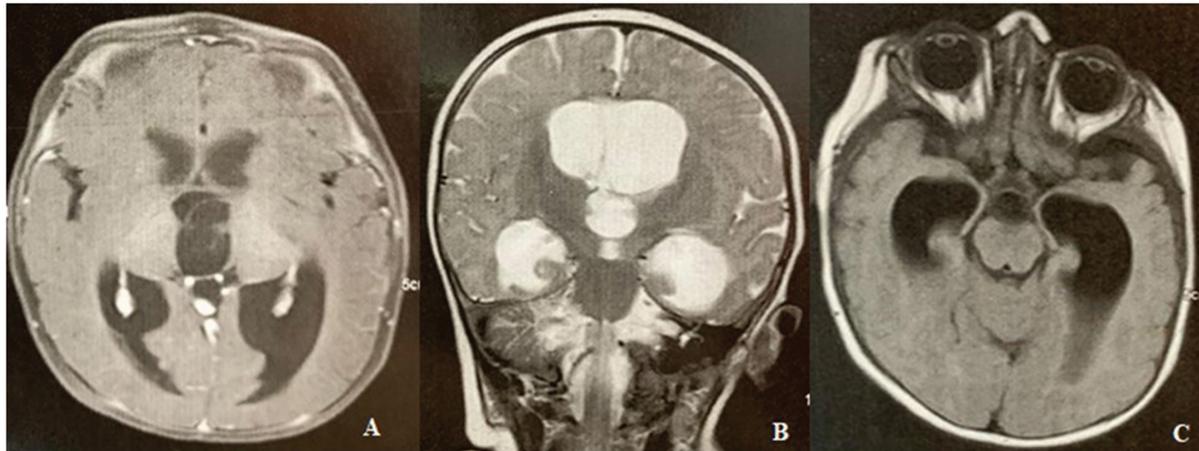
Preoperative cranial magnetic resonance imaging (MRI) scan showing a cystic lesion in the suprasellar region, obstructing the flow of cerebrospinal fluid (CSF) and causing obstructive hydrocephalus upstream. (A,C) Axial T1-weighted MRI of the skull. (B) Coronal T2-weighted MRI of the skull.
